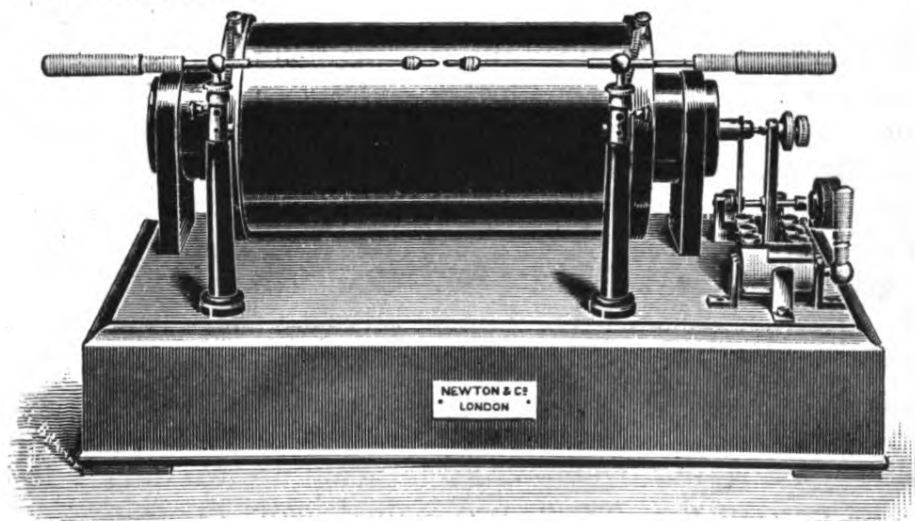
Induction coil for X-ray and high frequency work.
